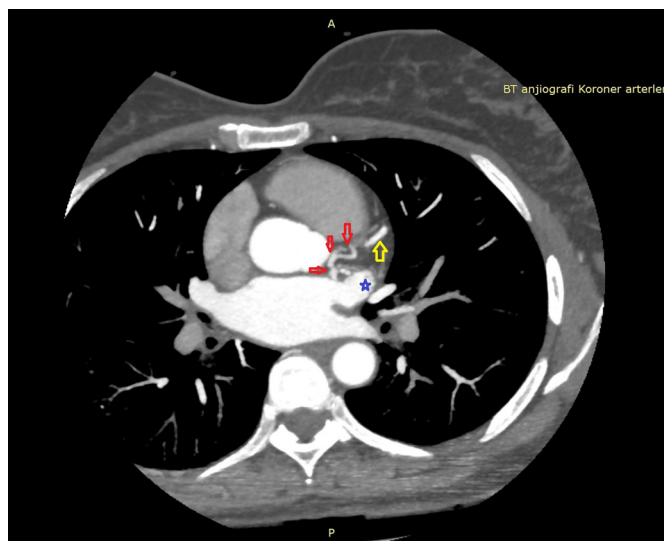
Case 2. Axial CT image, consecutive section following Figure 9. Blue star: LAA; red arrows: GCV; yellow arrow: LAD
